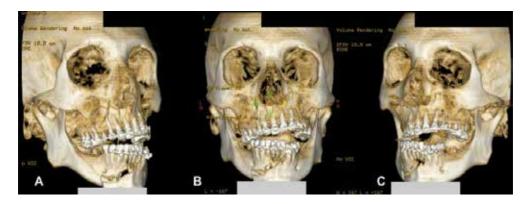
(A)–(C) – CT scan 3D reconstruction showing complex fracture and retrusion of the maxilla.
